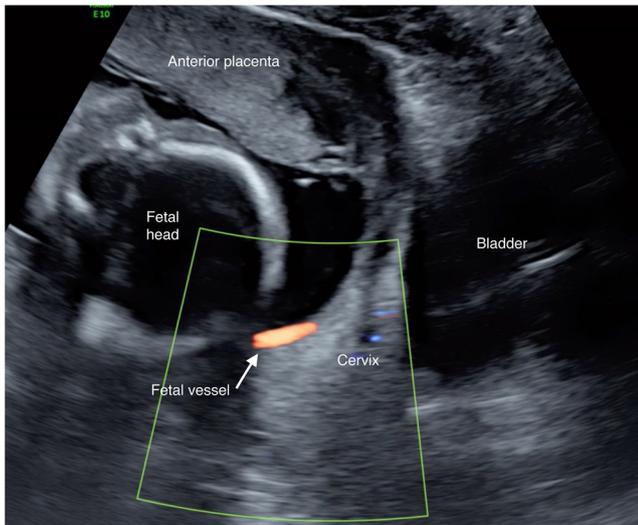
Transabdominal assessment of the lower uterine segment with colour Doppler
